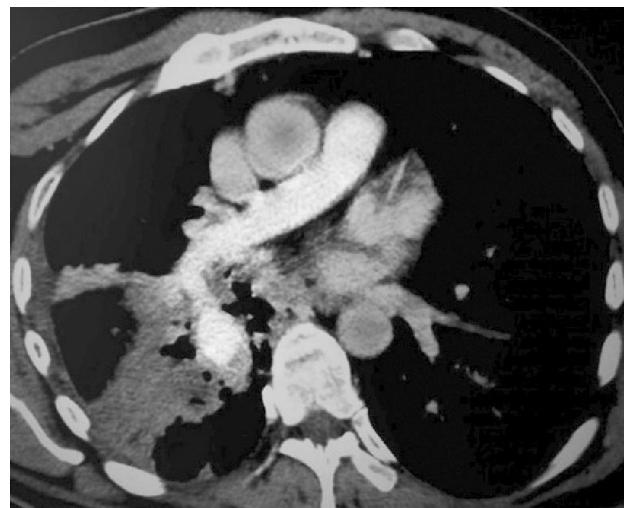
Contrast CT thorax in axial plane showing well defined intensely enhancing lesion in relation to wall of fluid filled cavity in right lower lobe.
